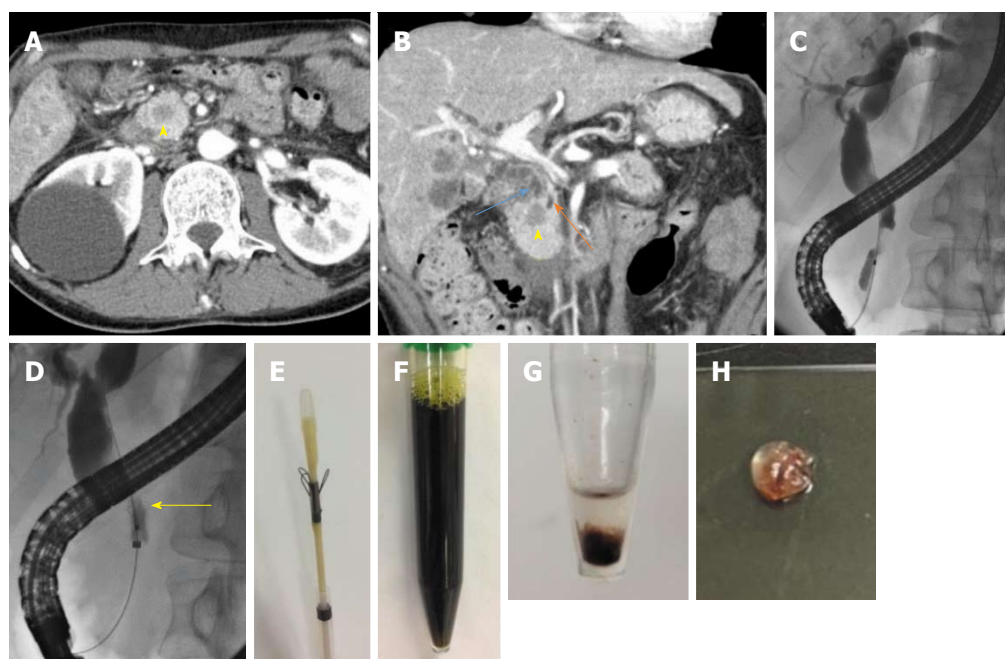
Imaging findings and samples obtained using the Trefle® device. A and B: Abdominal computed tomography indicated a poorly enhanced region (yellow arrowhead), dilated common bile duct (blue arrow), and upstream main pancreatic duct (orange arrow); C: Endoscopic retrograde cholangiopancreatography demonstrated a biliary stricture; D: The Trefle® device was inserted and opened, and the scraping loops were identified under fluoroscopic guidance (yellow arrow); E: Appearance of the Trefle® device; F: Appearance of samples obtained; G and H: Appearance of the centrifuged deposit.
